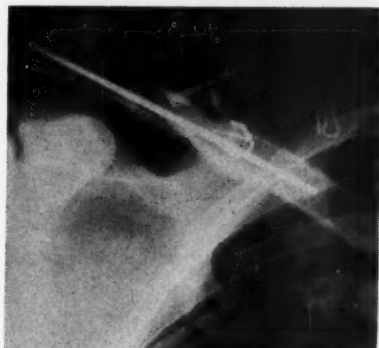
X-ray taken immediately after surgery. Wire loop was used to approximate two of the larger comminuted fragments. The patient had an 80 per cent full range of motion without pain on first postoperative day and returned to his job as carpenter on the fourth postoperative day.
